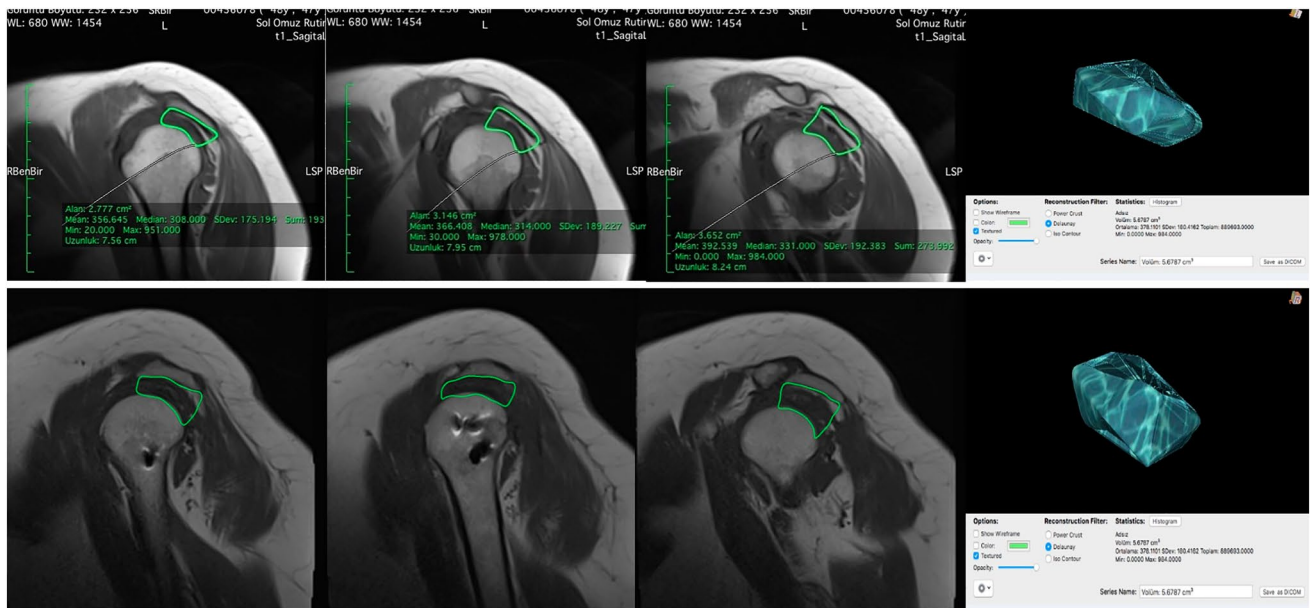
Subacromial volume measurement technique on MRI. The images demonstrate the subacromial volume measurements on the preoperative (upper row) and postoperative (bottom row) MRIs
